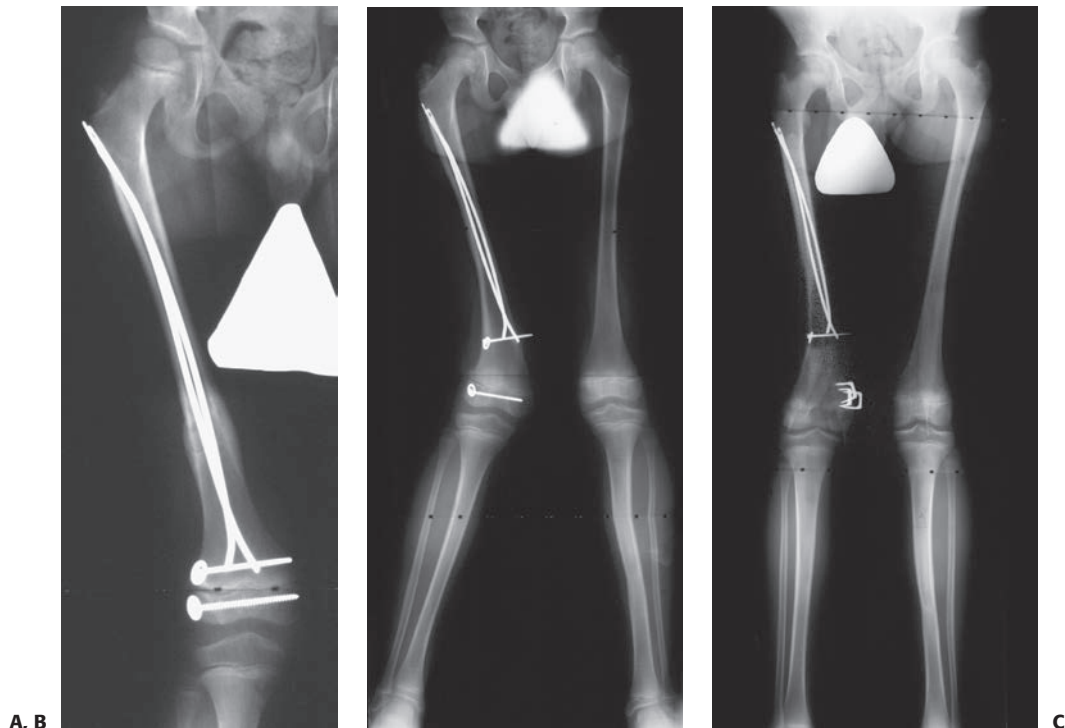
Growth deceleration in the absence of a true physeal arrest. This patient sustained concurrent ipsilateral femoral shaft and Salter–Harris type IV distal femoral epiphyseal fractures. A: Anteroposterior radiograph of the healed femur. Both fractures were treated with internal fixation. B: The patient developed valgus deformity of the distal femur because of asymmetric growth of the distal femoral physis. Note that the distance between the screws on either side of the physis has increased asymmetrically, confirming asymmetric growth rather than cessation of growth laterally. C: The angular deformity was treated with medial distal femoral epiphyseal stapling.
